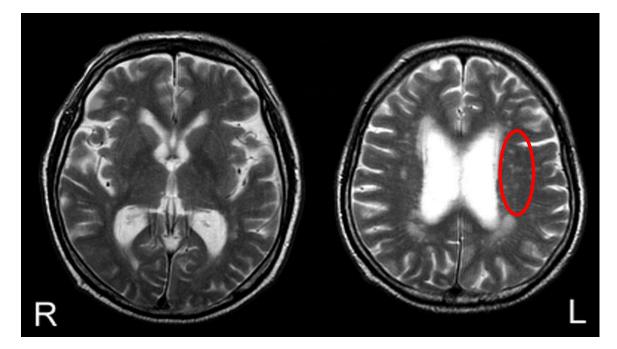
An example of a Brain MRI in a patient with PAF (74 years old, male) demonstrating ischemic small vessel lesions in cerebral white matter in the area circled.
